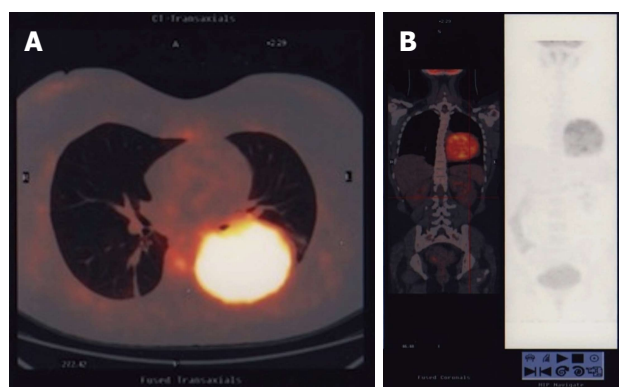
Computed tomography/positron emission tomography scan. A: CT-PET scan showing the large round mass in the left basal hemithorax; B: CT-PET scan showing a frontal vision of the mass inside the chest. CT-PET: Computed tomography/positron emission tomography.
